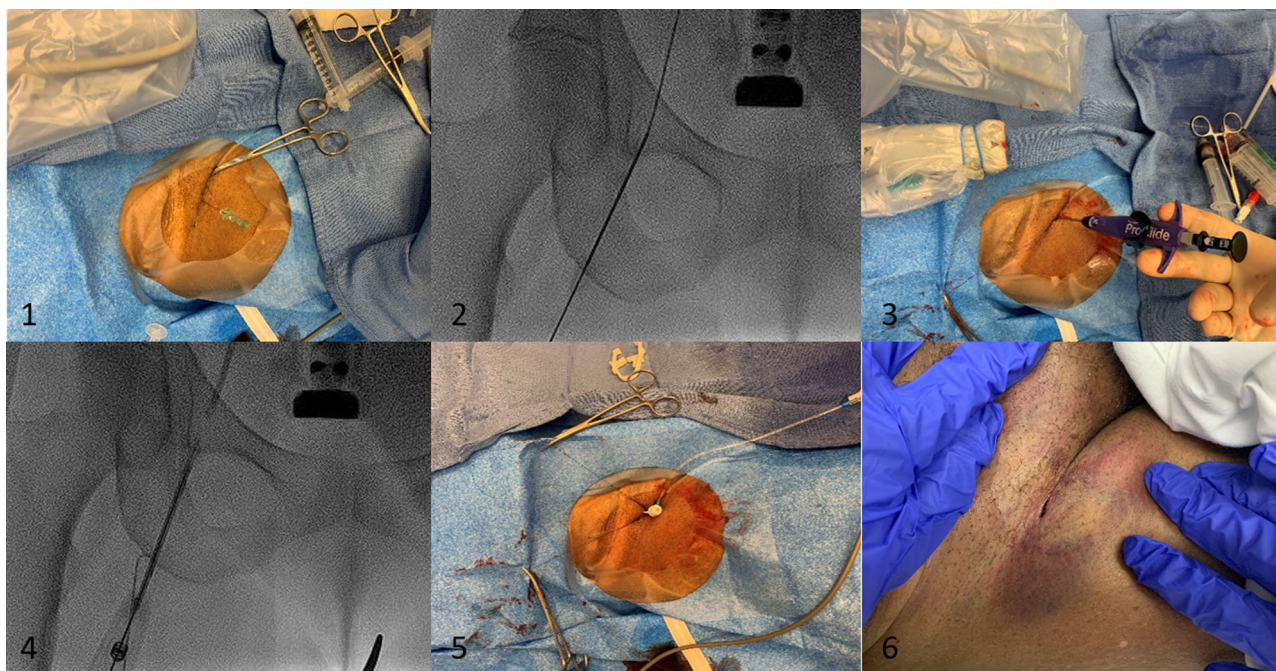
Steps for perclose deployment in big bore venous sheath. (1) Vascular access is obtained under ultrasound and fluoroscopic guidance using a micropuncture needle. (2) Needle placement is confirmed under fluoroscopy and guidewire is advanced. (3) After obtaining vascular access, the Perclose device is inserted and positioned over the wire using standard technique. (4) Fluoroscopy is used to verify correlation of Perclose foot plate with access site. (5) Perclose sutures are secured with clamps before large bore venous sheath insertion. (6) Femoral vein access at the completion of the case after Perclose sutures are tied and cut and hemostasis is obtained. [Color figure can be viewed at wileyonlinelibrary.com]
